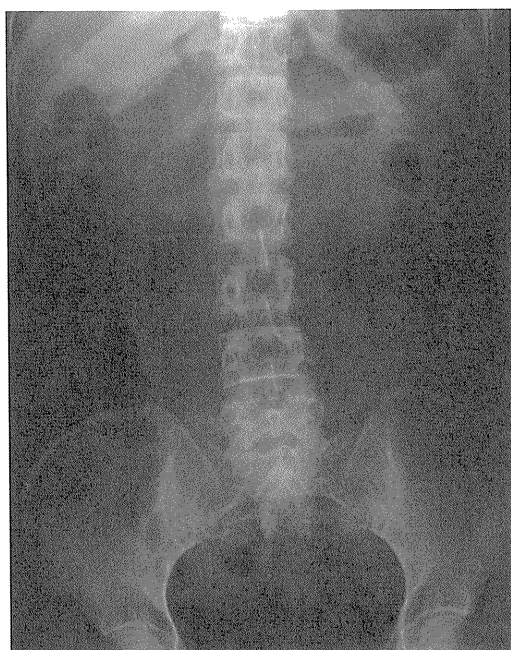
Abdominal radiograph just after double-balloon enteroscopy via the transanal approach with carbon dioxide insufflation. Minimal residual gas retention is visible in the small and large bowels (classified as grade 2).
